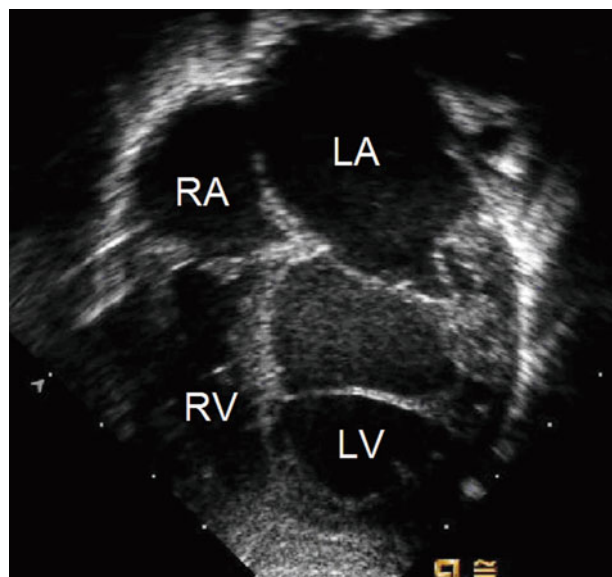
An echocardiogram displaying severe left ventricular and atrial dilation. LA left atrium, LV left ventricle, RA right atrium, RV right ventricle
